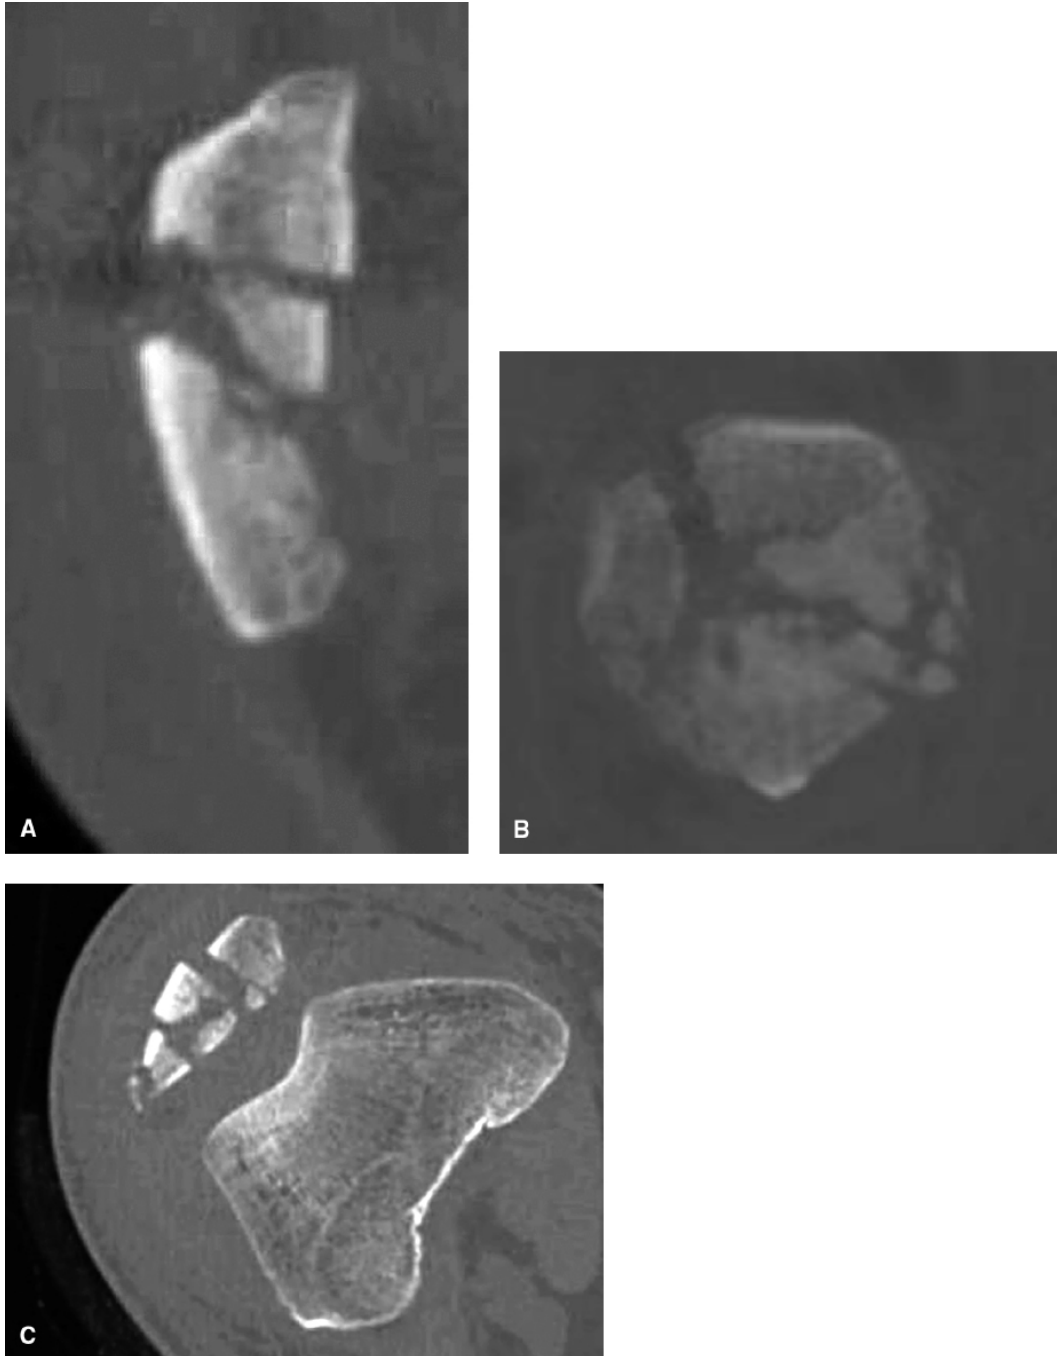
A–C: CT scan of comminuted patella fracture.
